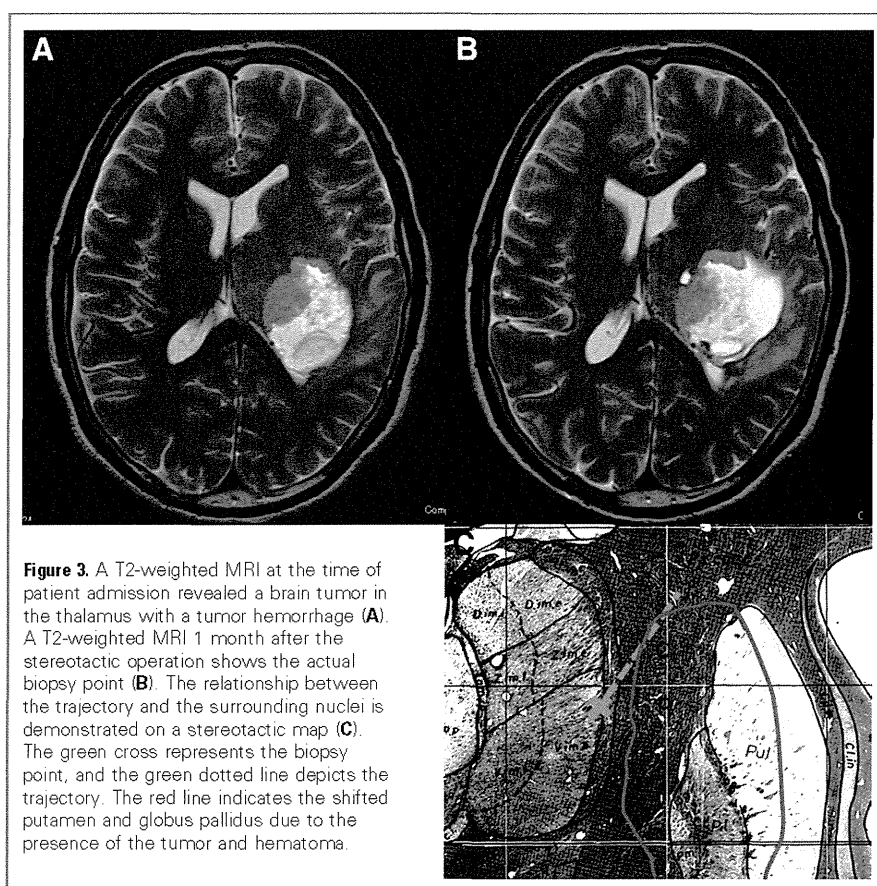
A T2-weighted MRI at the time of patient admission revealed a brain tumor in the thalamus with a tumor hemorrhage (A). A T2-weighted MRI 1 month after the stereotactic operation shows the actual biopsy point (B). The relationship between the trajectory and the surrounding nuclei is demonstrated on a stereotactic map (C). The green cross represents the biopsy point, and the green dotted line depicts the trajectory. The red line indicates the shifted putamen and globus pallidus due to the presence of the tumor and hematoma.
